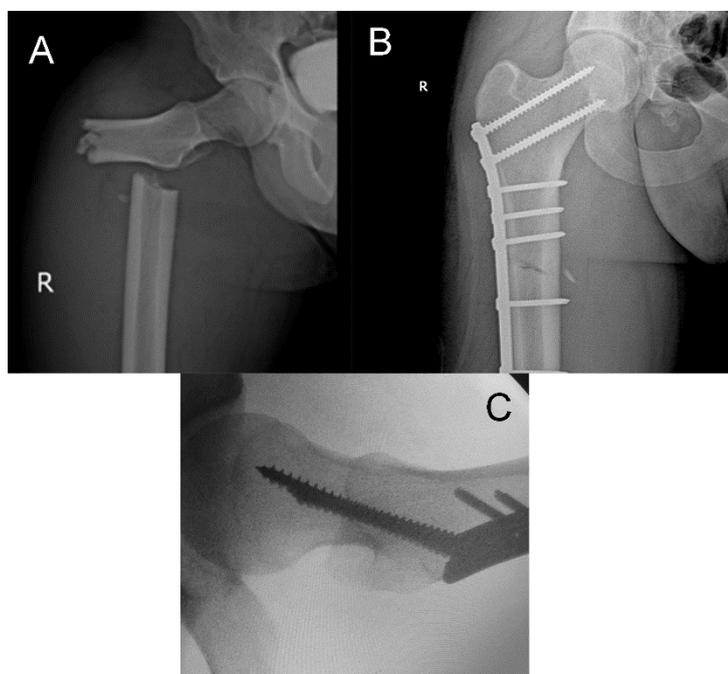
A: Pre-operative radiography of a femoral subtrochanteric fracture. B: Early post-operative anteroposterior X-ray. C: Intraoperative true lateral view of the hip at the lateral decubitus position
